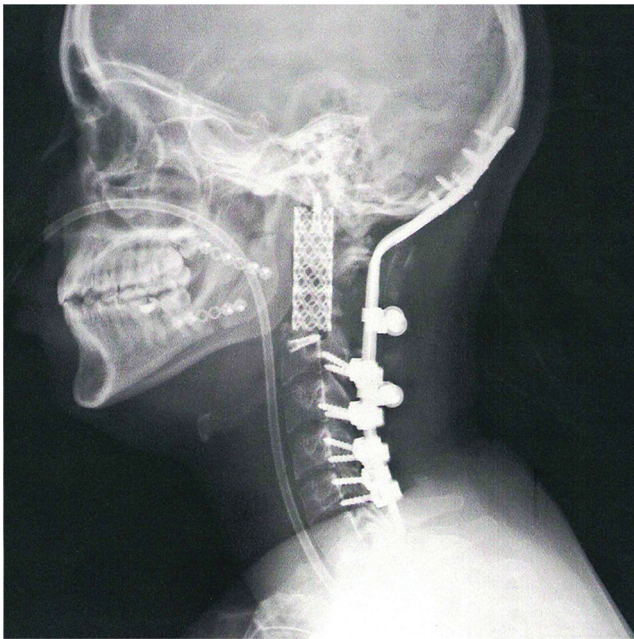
Postoperative lateral view radiograph demonstrating anterior and posterior occipitocervical fixation with osteotomy of the angle of the mandible.
